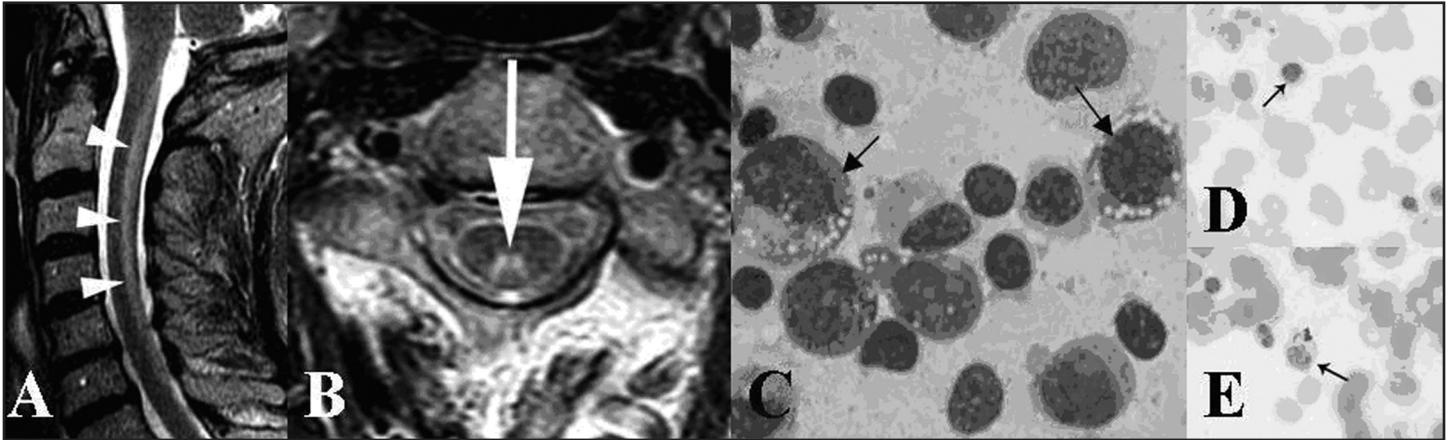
A and B Sagittal (A) and axial (B) T2-weighted magnetic resonance images in a patient with copper deficiency myelopathy showing increased signal in the paramedian aspect of the dorsal cervical cord. C, D, and E Bone marrow studies from patients with copper deficiency myelopathy showing vacuolated myeloid precursors (C), ringed sideroblast (D), and iron containing plasma cell (E).
